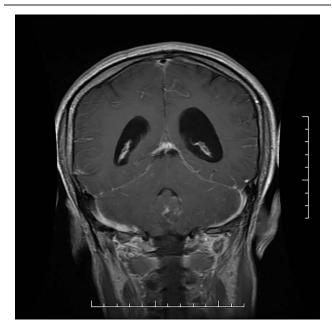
Enhanced magnetic resonance imaging of head revealed bilateral cerebral and cerebellar hemispheres abnormal meningeal enhancement.
